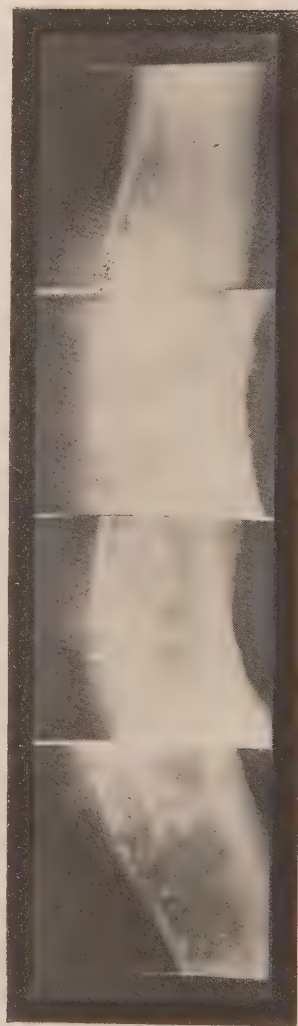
Radiograph of spinous process. Condition several years after teeth were extracted. (Courtesy of Dr. William A. Colburn.)
